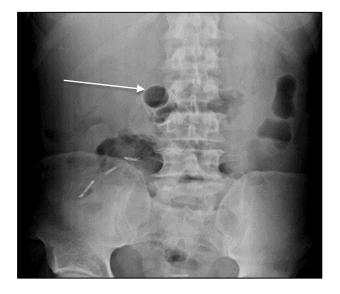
Duodenal stent on adequate position, control radiography after endoscopy.
